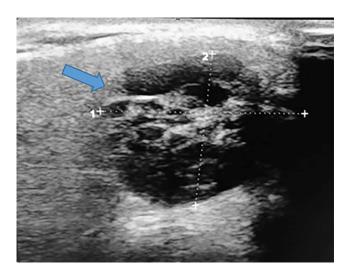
Ultrasound of the right parotid gland: well-defined mass with lobulated contours, tissue containing hypoechoic areas (blue arrow).
